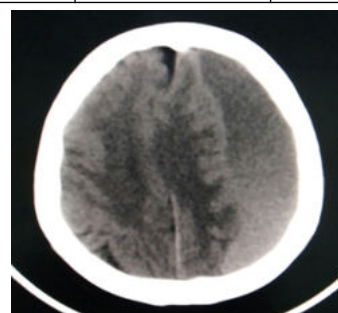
CHRONIC SDH CT SCAN IMAGE
